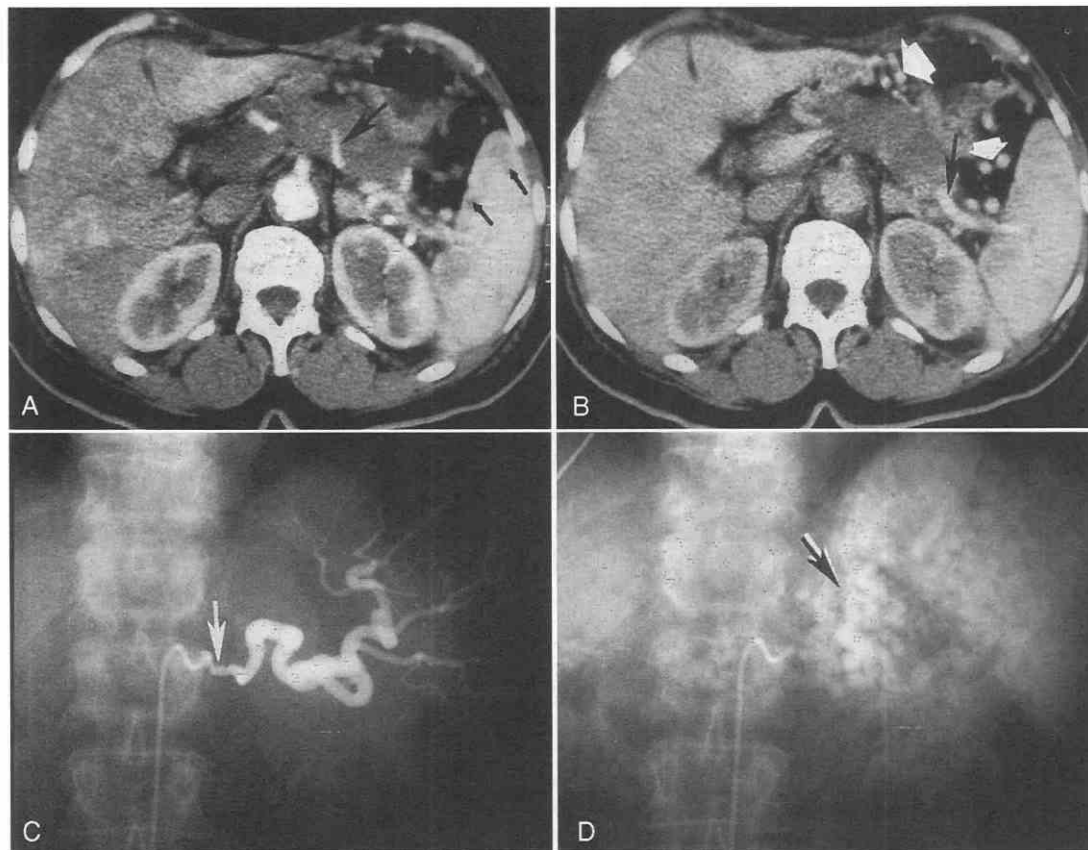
This set of images has been retained for historical purposes. With the advent of the new multislice devices, it is very likely such direct angiograms for diagnosis of pancreatic cancer will never be performed in the future. *A*, CT scan of pancreatic mass with encasement of the splenic artery (*large arrow*), which is producing low-density areas (*small arrows*) in the spleen. *B*, Scan taken at a later phase shows the splenic vein (*black arrow*) and collateral veins in the perisplenic area and the left gastric area (*white arrows*). *C*, Arteriogram showing encasement (*arrow*) of the origin of the splenic artery. *D*, Numerous venous collaterals in the perisplenic area (*arrow*) produced by occlusion of the splenic vein.
